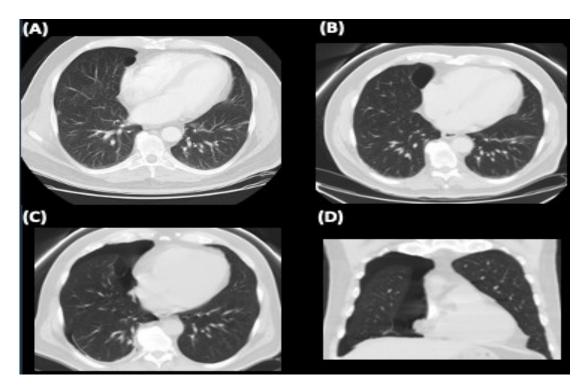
Case one. (A) Chest CT taken 11 years prior to presentation showing right middle-lobe bulla. (B) Chest CT Scan 2 months prior to presentation for an unrelated reason. Note the interval growth of the bulla from Fig 1A. (C-D) Chest CT was obtained at presentation with axial (C) and sagittal (D) images showing the bulla and right-sided pneumothorax.
